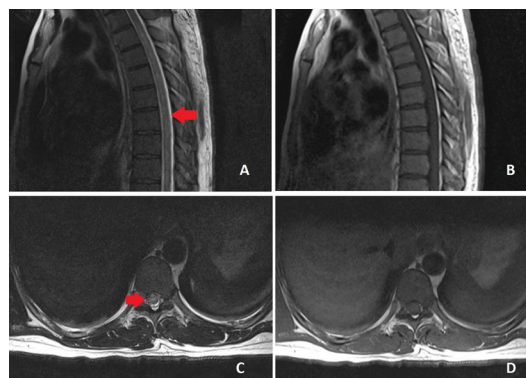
MRI of the spine showing diffuse patchy abnormal T2-hyperintense signals from T2-L1 vertebrae (red arrows in panels A and C) without contrast enhancement on T1-post contrast images (panels B and D).
